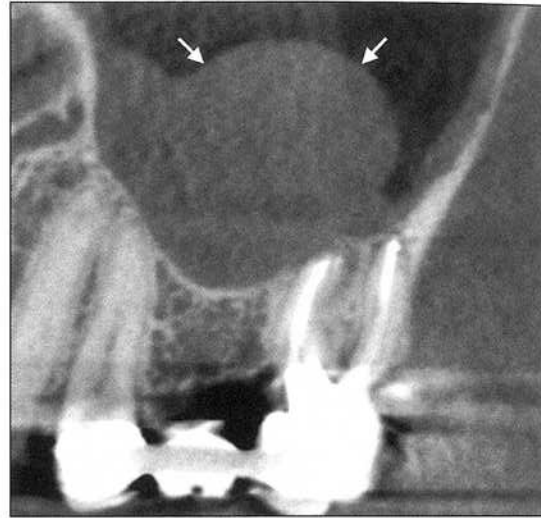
Periapical mucositis. Sagittal CBCT image of a failing root canal treatment of the maxillary left second molar. Apical periodontitis has perforated the antral cortex and associated periosteum, causing a localized inflammatory edema of the adjacent sinus mucosa (arrows). Note the lack of any evident osseous changes in the alveolar bone or sinus floor.
